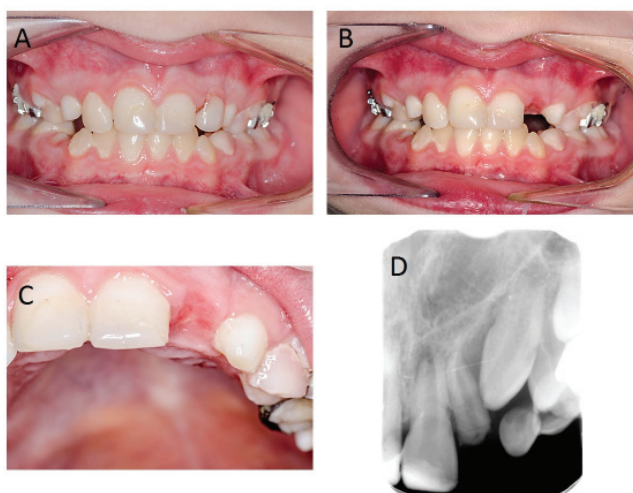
A, B – patient after 15-month follow-up period with and without the attached acrylic tooth #22. Slight inflammation of the mucosa observed in the injured region can be attributed to the poor oral hygiene combined with the contact with the acrylic resin. C – the bone loss in the horizontal aspect can be hardly observed. D – dental radiograph taken after 15-month follow-up period: apex of the root of the tooth #22 is closed; previously exposed pulp area is covered with radiopaque tissue
